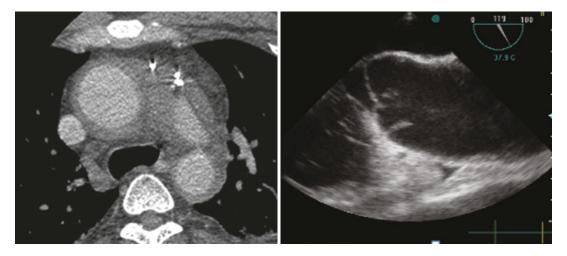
A patient with intramural haematoma demonstrated on CT with thickening of the aortic wall which was difficult to see on echo but the TOE images also detected a dissection flap in the root close to the aortic leaflets
